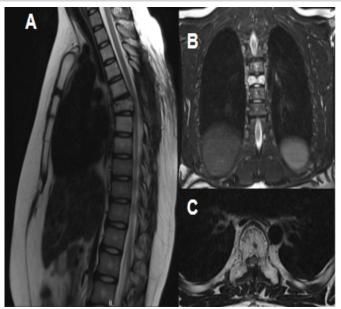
Magnetic resonance imaging: Signs of surgical manipulation, a slight increase in the amplitude of the cerebrospinal fluid space in the spinal canal, and a reduction in the T2 hyperintensity in the dorsal spinal cord at the T6 level. There is a significant reduction in the height of the T6 vertebral body, presenting kyphosis in image A.
